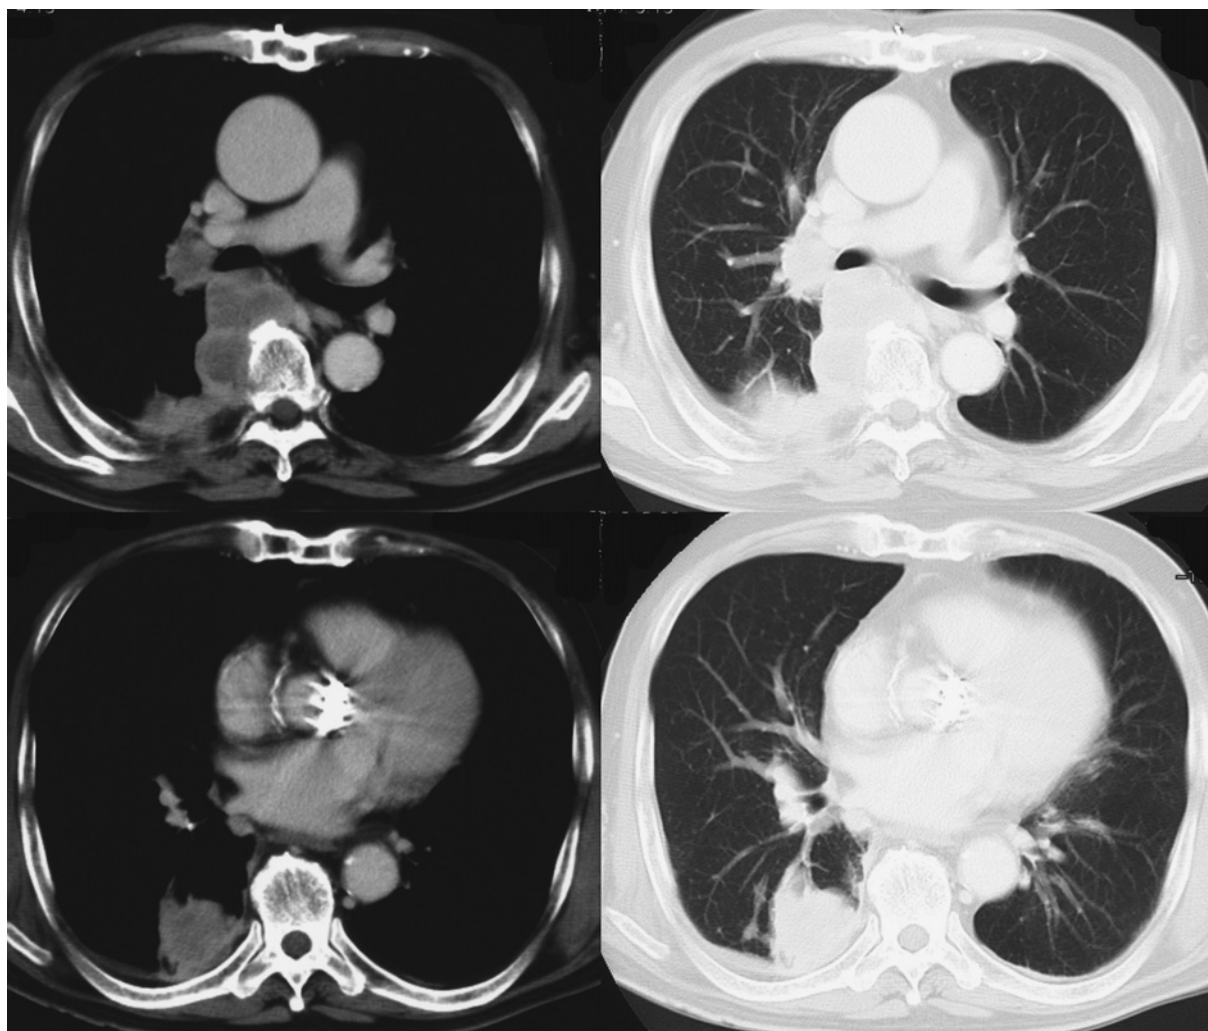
Computed tomography of the chest. An axial image revealed a low density mass extending into the ribs, vertebra, upper lung, spine, hilar lymph node, and mediastinal lymph nodes.
